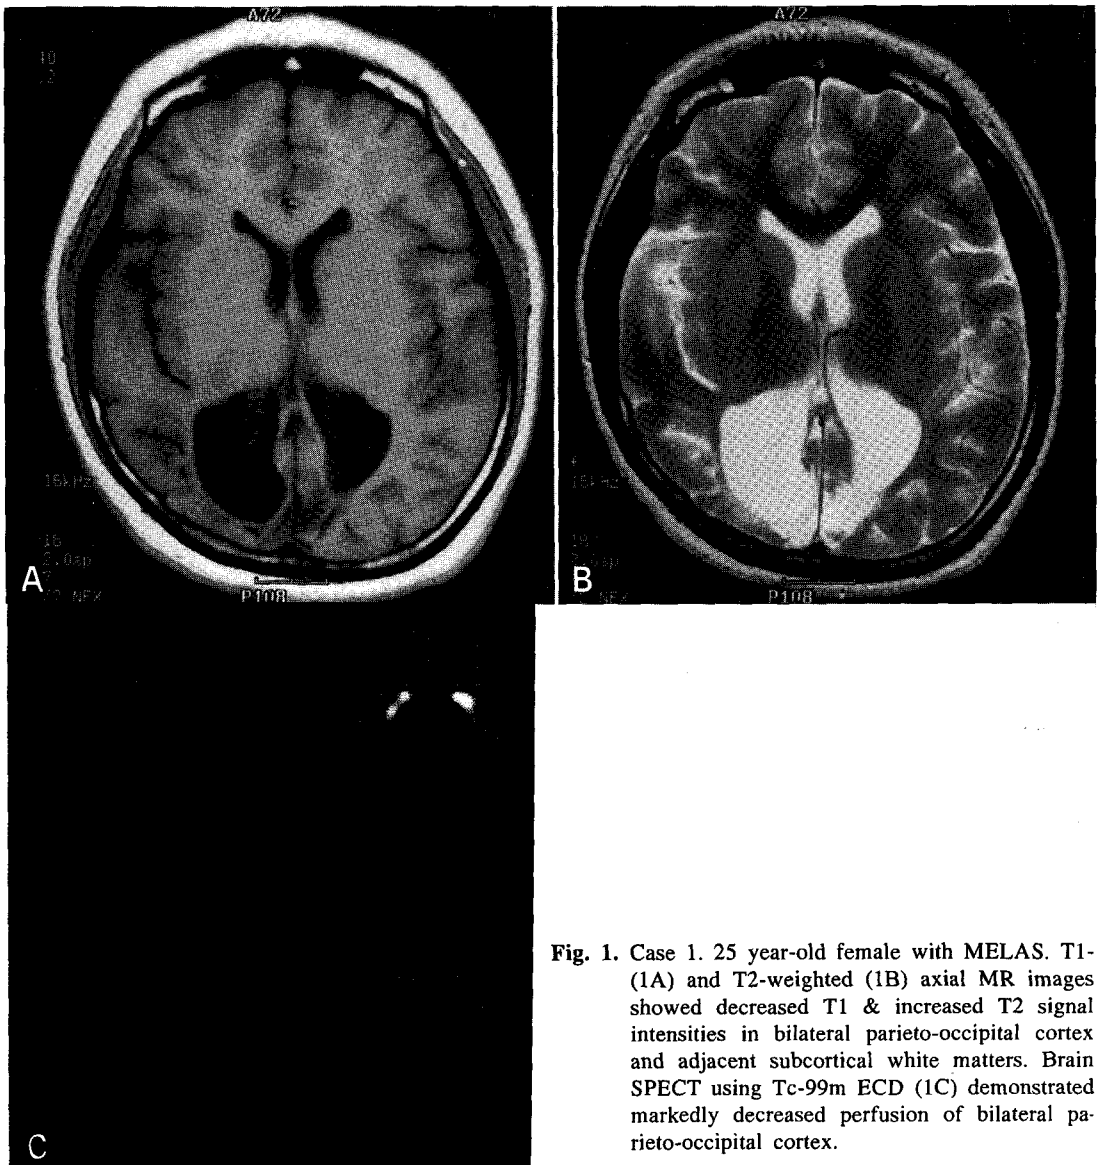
Case 1. 25 year-old female with MELAS. T1- (1A) and T2-weighted (1B) axial MR images showed decreased T1 & increased T2 signal intensities in bilateral parieto-occipital cortex and adjacent subcortical white matters. Brain SPECT using Tc-99m ECD (1C) demonstrated markedly decreased perfusion of bilateral parieto-occipital cortex.
